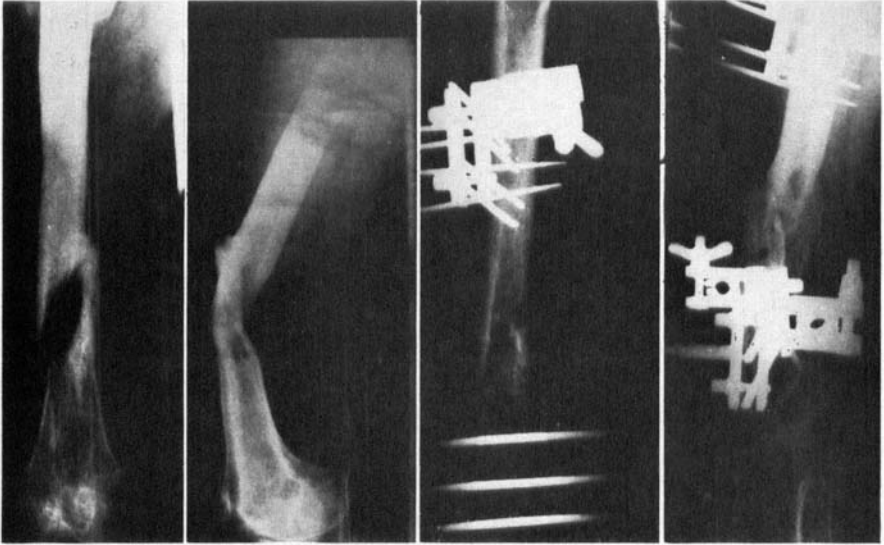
Roentgenograms of Case 3 (see text).*
